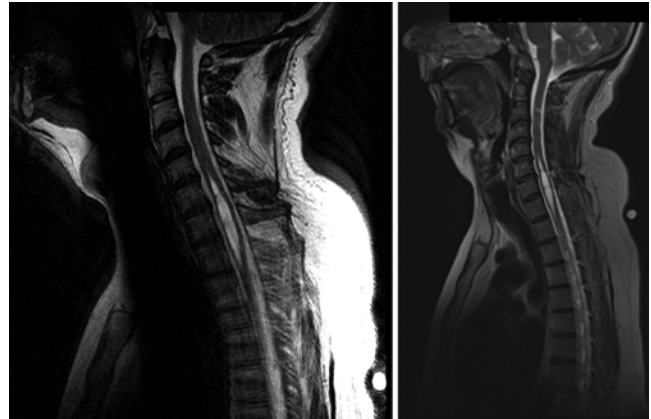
Case 5. Sagittal T2-weighted images obtained at presentation (left) and at the 10-year follow-up (right).
